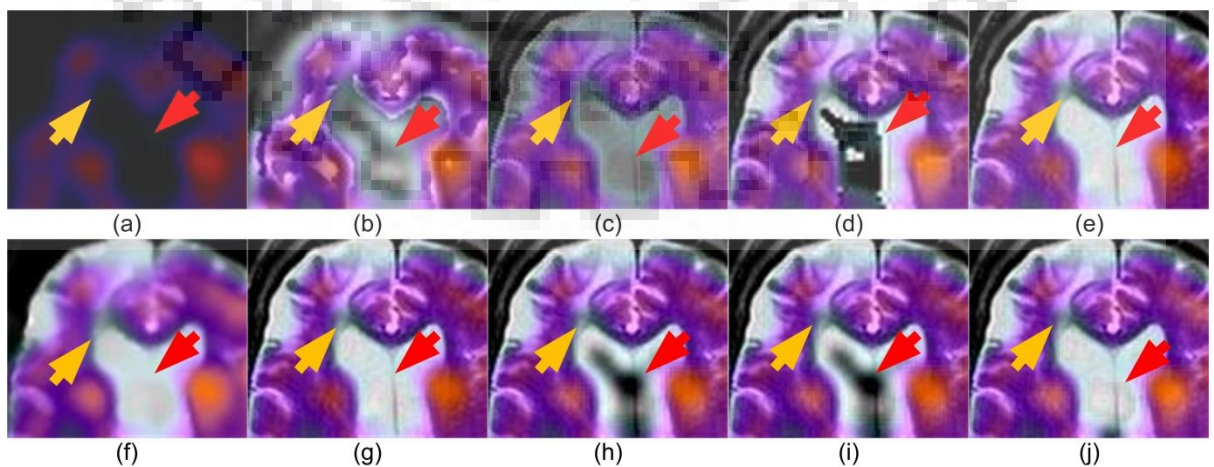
Zoomed region of the fusion results of another MR-SPECT image pair-4, fused images obtained by the (a) Method 1 (b) Method 2 (c) Method 3 (d) Method 4 (e) Method 5 (f) Method 6 (g) Method 7 (h) Method 8 (i) Method 9 (j) Method 10
